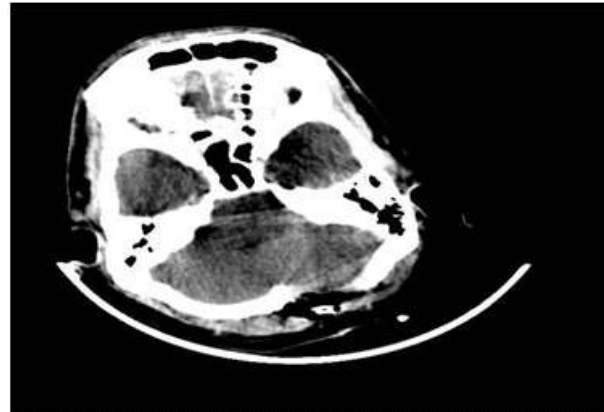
Postoperative CT of case 2
